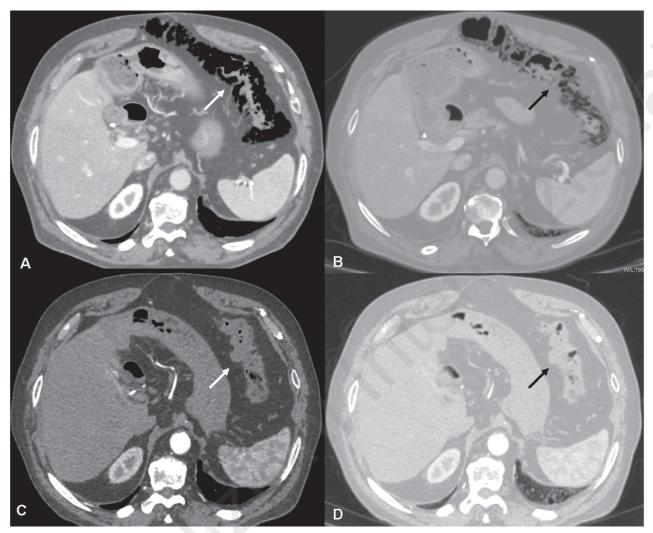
Transverse CT scans (A, soft tissue window; B, lung parenchyma window) show pneumatosis cystiodes intestinalis of the colon represented by multiple gas-filled intramural cysts (arrow) in an adult liver recipient. The CT control after 4 weeks of conservative therapy shows a complete resolution of the disease (arrow) (C, soft tissue window; D, lung parenchyma window).
